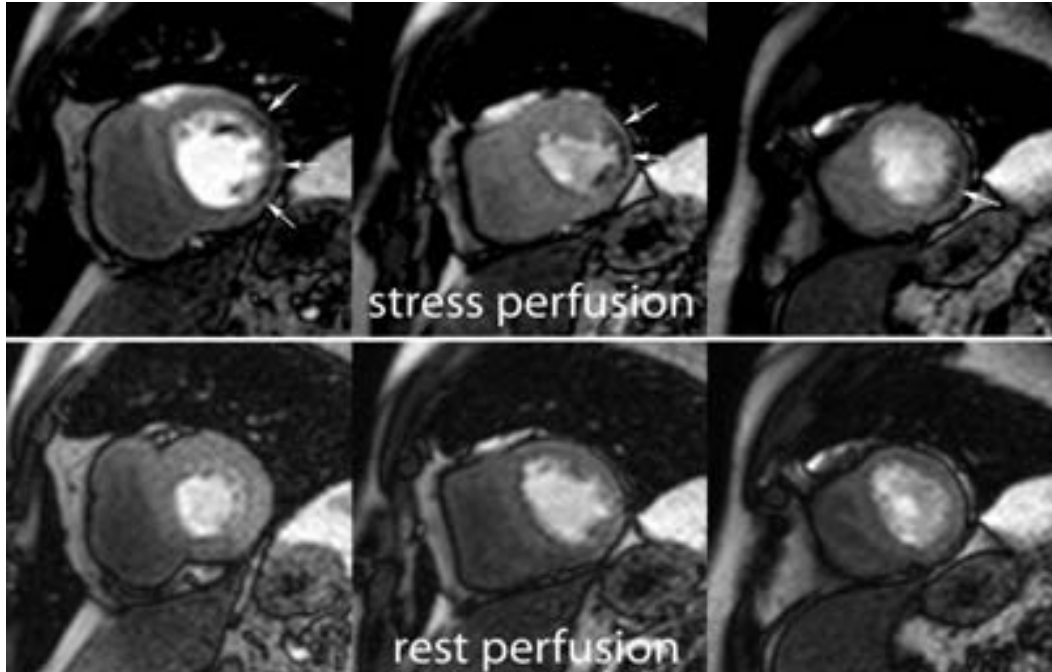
CMR rest and stress perfusion imaging in a case with stable angina. Mid ventricular short-axis cardiac MRI images of first pass perfusion during rest (bottom) show no perfusion defects while during Dipyridamole vasodilatory stress (top) show a sub-endocardial perfusion defect in the lateral wall (arrows)<sup>19</sup>
